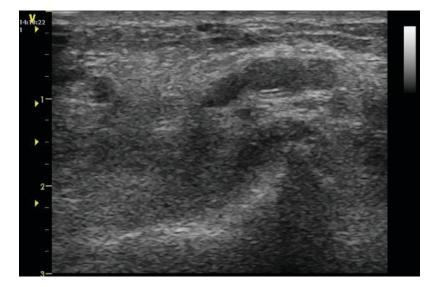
The tip of the central line can be detected by ultrasound, subcostal. The catheter is visible like in the cavo-atrial junction. Sectorial probe 5 mhz
